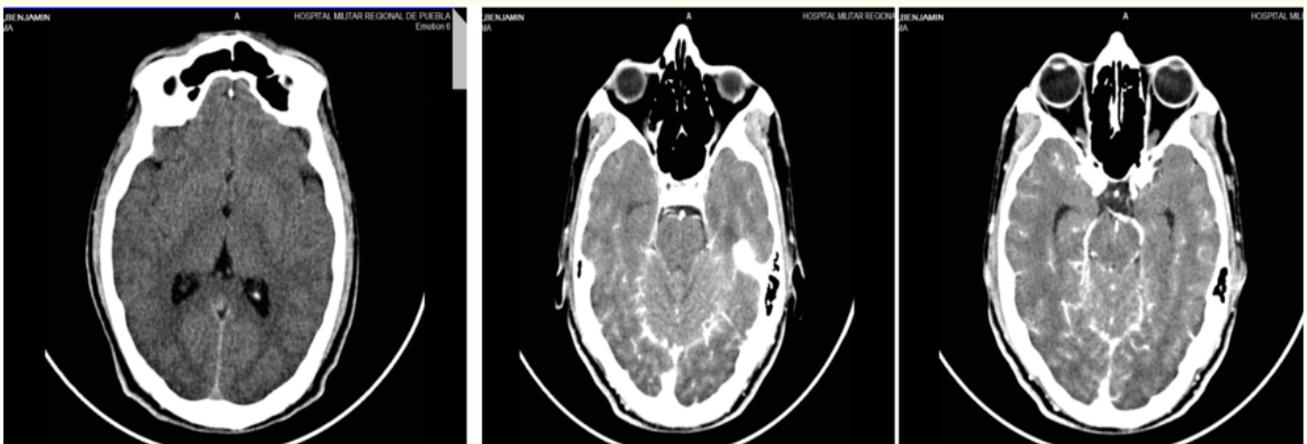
Computed tomography of the skull. A. Simple phase B and C. Contrast phase where meningeal reinforcement is observed.
